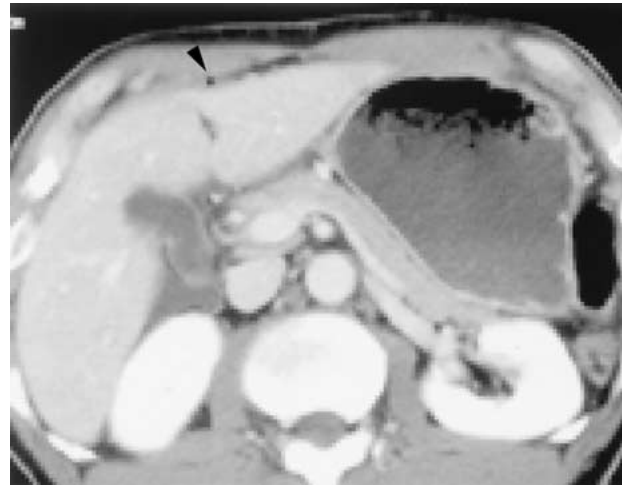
Contrast-enhanced CT image in a patient with duodenal perforation. An air bubble is seen at the anterior peritoneal surface of the liver (*arrowhead*).
